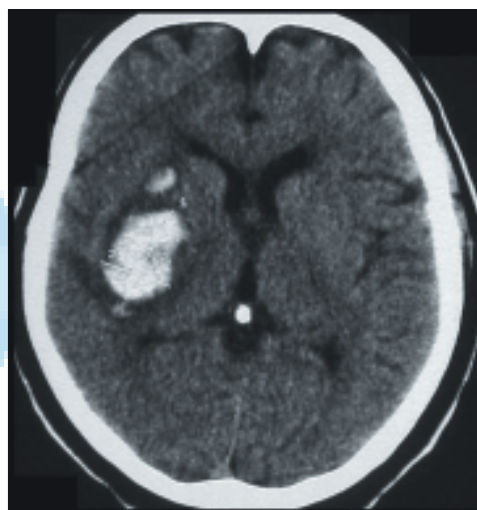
CT Brain showing right basal ganglionic bleed
